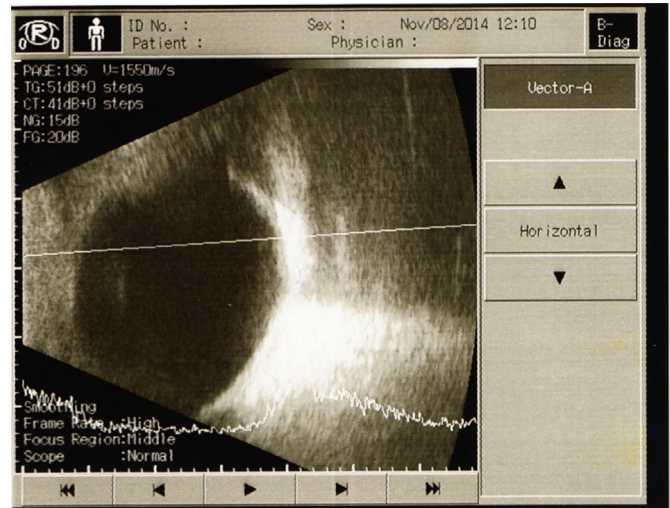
Ultrasound of both eyes showed A scan with high intensity echo spikes and highly reflective choroidal mass with posterior acoustic shadowing in favor of posterior globe calcification.
